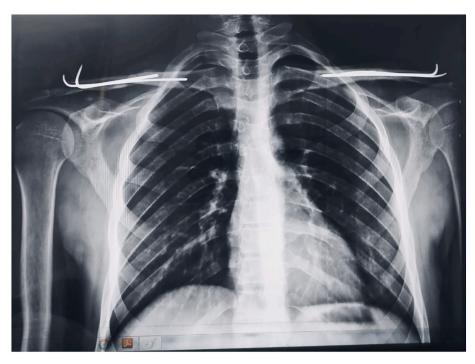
X-rays at the third month postoperative: fusion of the fracture on both sides.
